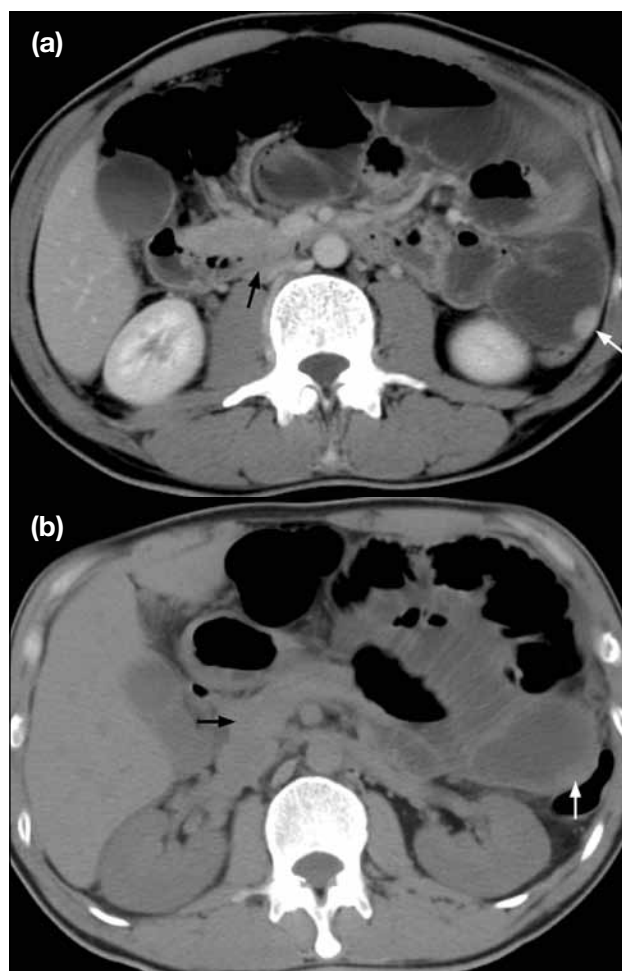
A 36-year-old man operated for acute appendicitis presented with abdominal pain and vomiting on his postoperative day 3. (a) Contrast-enhanced axial computed tomographic (CT) image of the abdomen shows an enhancing submucosal nodule in the mid jejunum (white arrow); the normal pancreatic head (black arrow) is shown. (b) Similarly, axial non-contrast CT shows the similar density subtle nodule in the proximal jejunum (white arrow); the pancreatic head is shown (black arrow). Also note the fluid-filled dilated small bowel loops consistent with small bowel obstruction.
